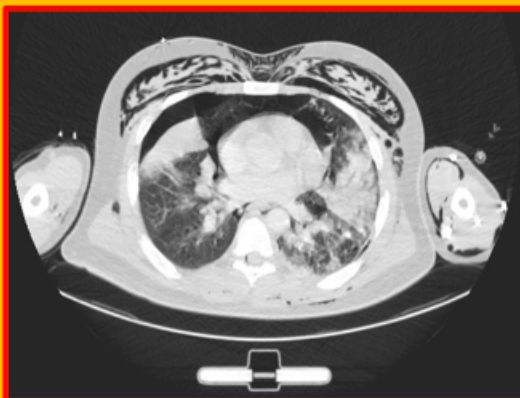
CT scan showing significant subcutaneous emphysema, right-sided pneumothorax and bilateral consolidation.
